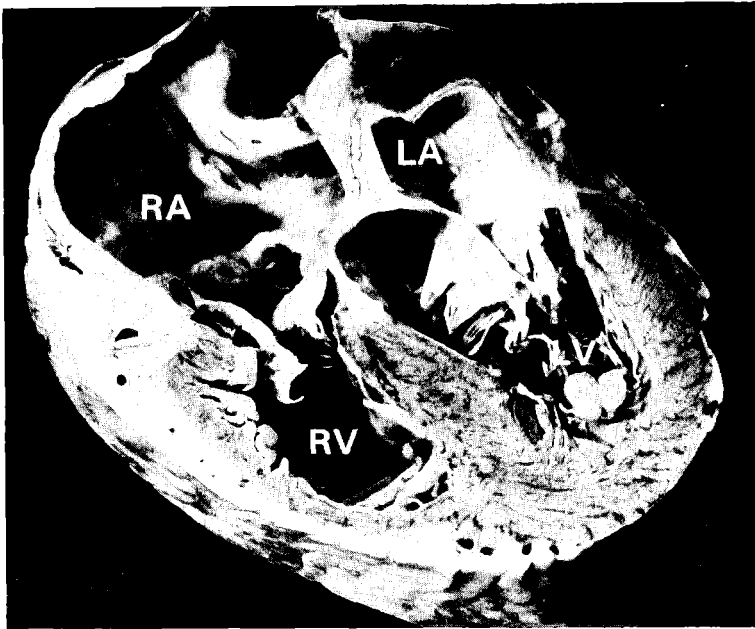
Anatomic cross-sections through the heart and corresponding transesophageal two-dimensional echocardiograms. The transducer is positioned at the level of the left atrium (LA). A, Shows cross-sections obtained with a superior tilt of the transducer. This view typically shows the short axis of the superior caval vein (SCV), aorta (Ao) and pulmonary artery (PA); B, A slightly inferior tilt of the transducer allows identification of the left atrial appendage (asterisk), the left coronary artery (arrow), the aorta, the right atrium (RA) and the pulmonary valves (PV); C, More inferiorly the left ventricular outflow tract and mitral valve can be studied; D, Characteristically, the cardiac four-chamber view is observed with the transducer tilted even more inferiorly. LA = left atrium; RA = right atrium; LV = left ventricle; RV = right ventricle.
